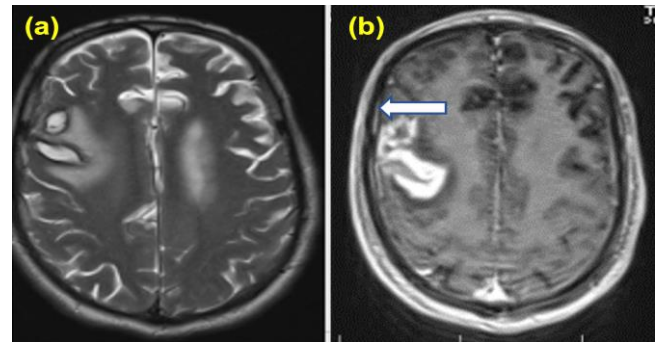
Brain MRI (a) Axial T2-weighted image showing a heterogeneous cortical ill-defined lesion in the right frontal lobe with perilesional oedema. (b) Axial plane of post-contrast T1-weighted image showing intense cortical enhancement and adjacent meningeal enhancement (white arrow).
